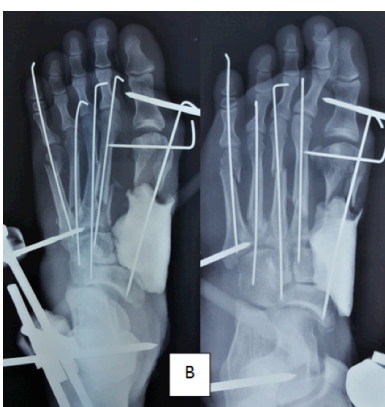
Figure B shows the plain radiographs (antero-posterior and oblique views) after wound debridement, Kirschner wires insertion, antibiotic cement spacer insertion and cross-ankle external fixation.
